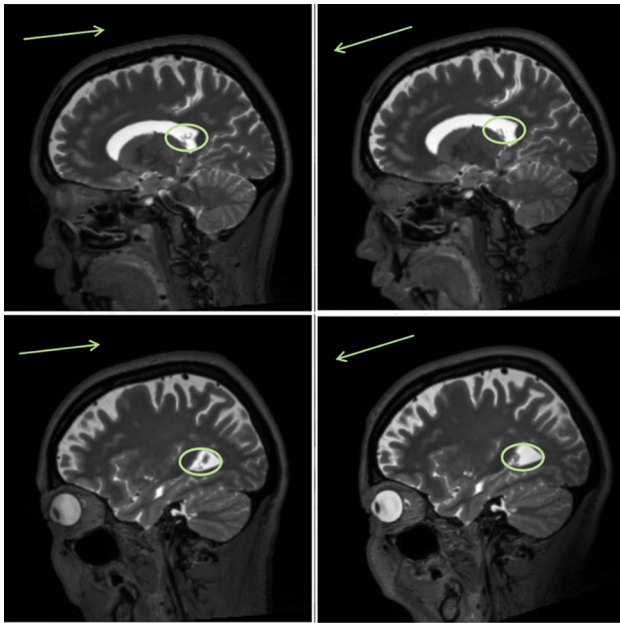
Example images of one participant showing choroid plexus position (circled, dark line within lateral ventricle) in supine (left) and prone (right) MRI images
